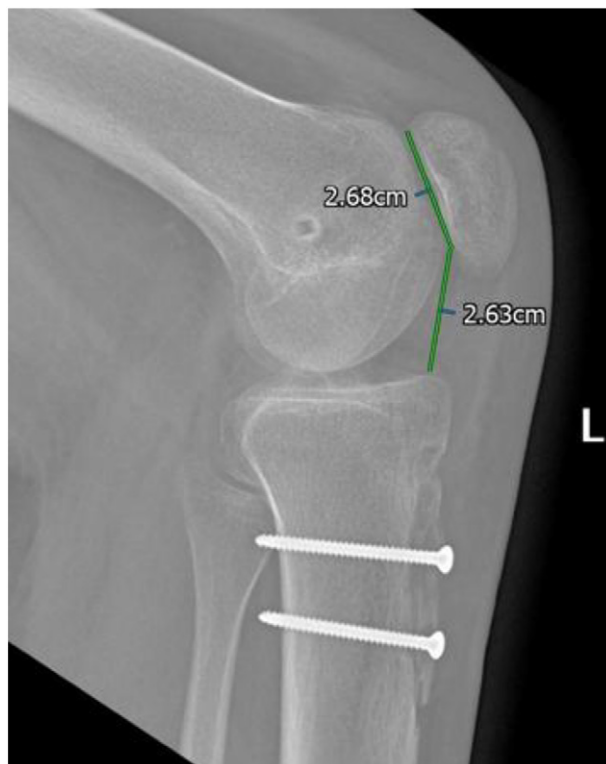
X-ray showing combined TT distalisation + MPFL Reconstruction.
